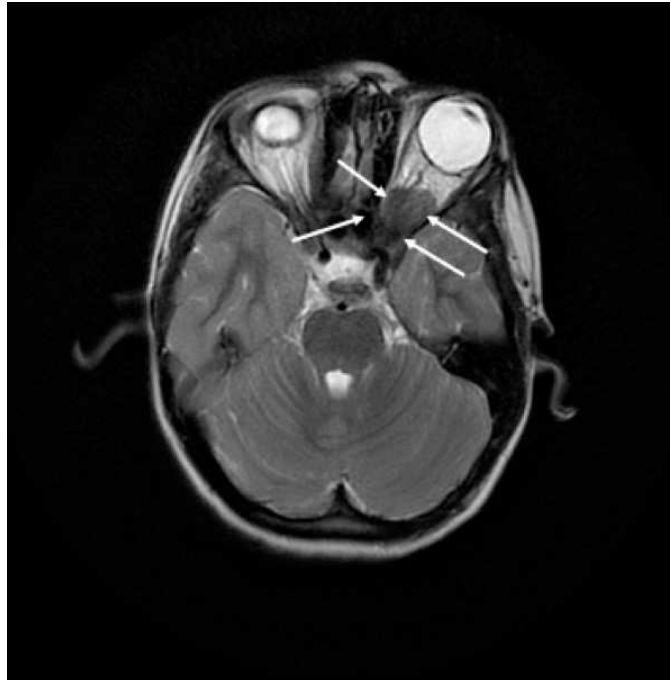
Axial, T2-weighted MRI of the patient, at 10 years of age. A left optic meningioma (white arrows) compresses the optic nerve.
